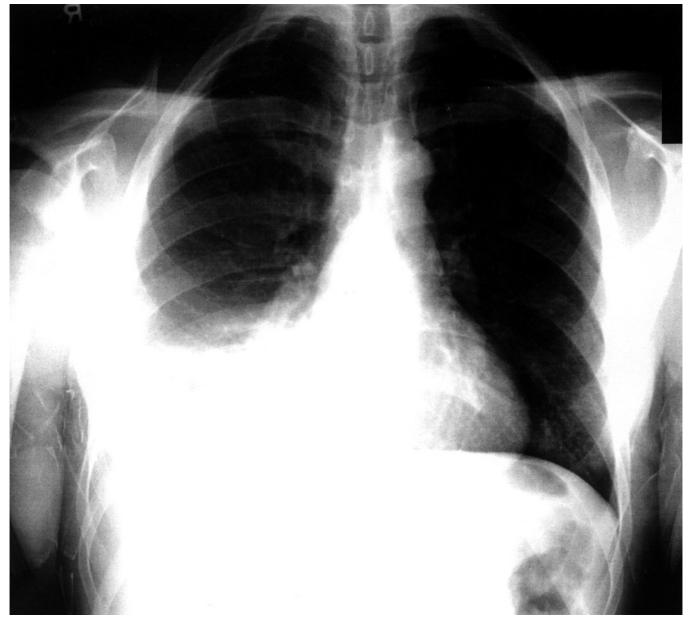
A 44 year old man with HIV infection and CD4 count of 326 per cubic milliliter presented with a two-day history of fever, productive cough and chest pain. His chest radiograph shows a right middle lobe in Itrate and a large rght pleural effusion. Blood cultures grew *S. pneumoniae*. After drainage of 0.5L of pleural uid and treatment with ceftriaxone, the patient improved.
